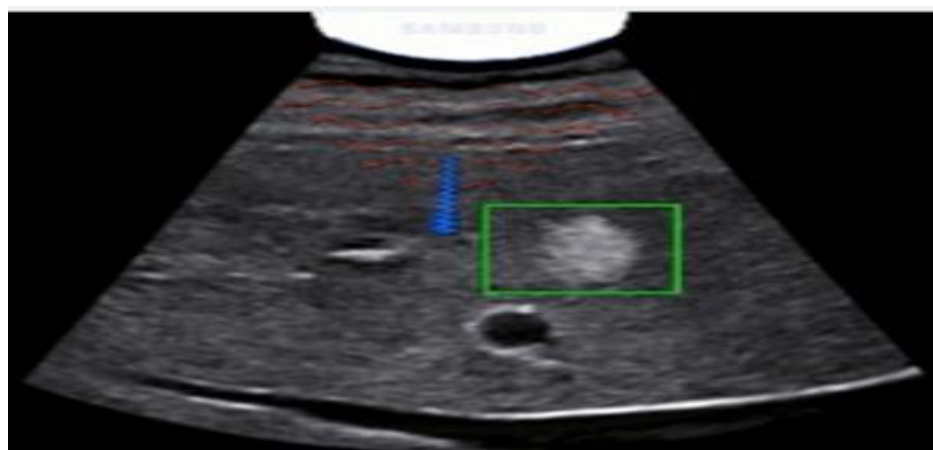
Graphic depiction of an ultrasound pulse (blue arrow)and resultant shear waves (red perpendicular waves)used during shear wave elastography . The shear waves propagate through the region of interest (green box) to determine the stiffness of the liver tissue /lesion⁽¹⁶⁾.
